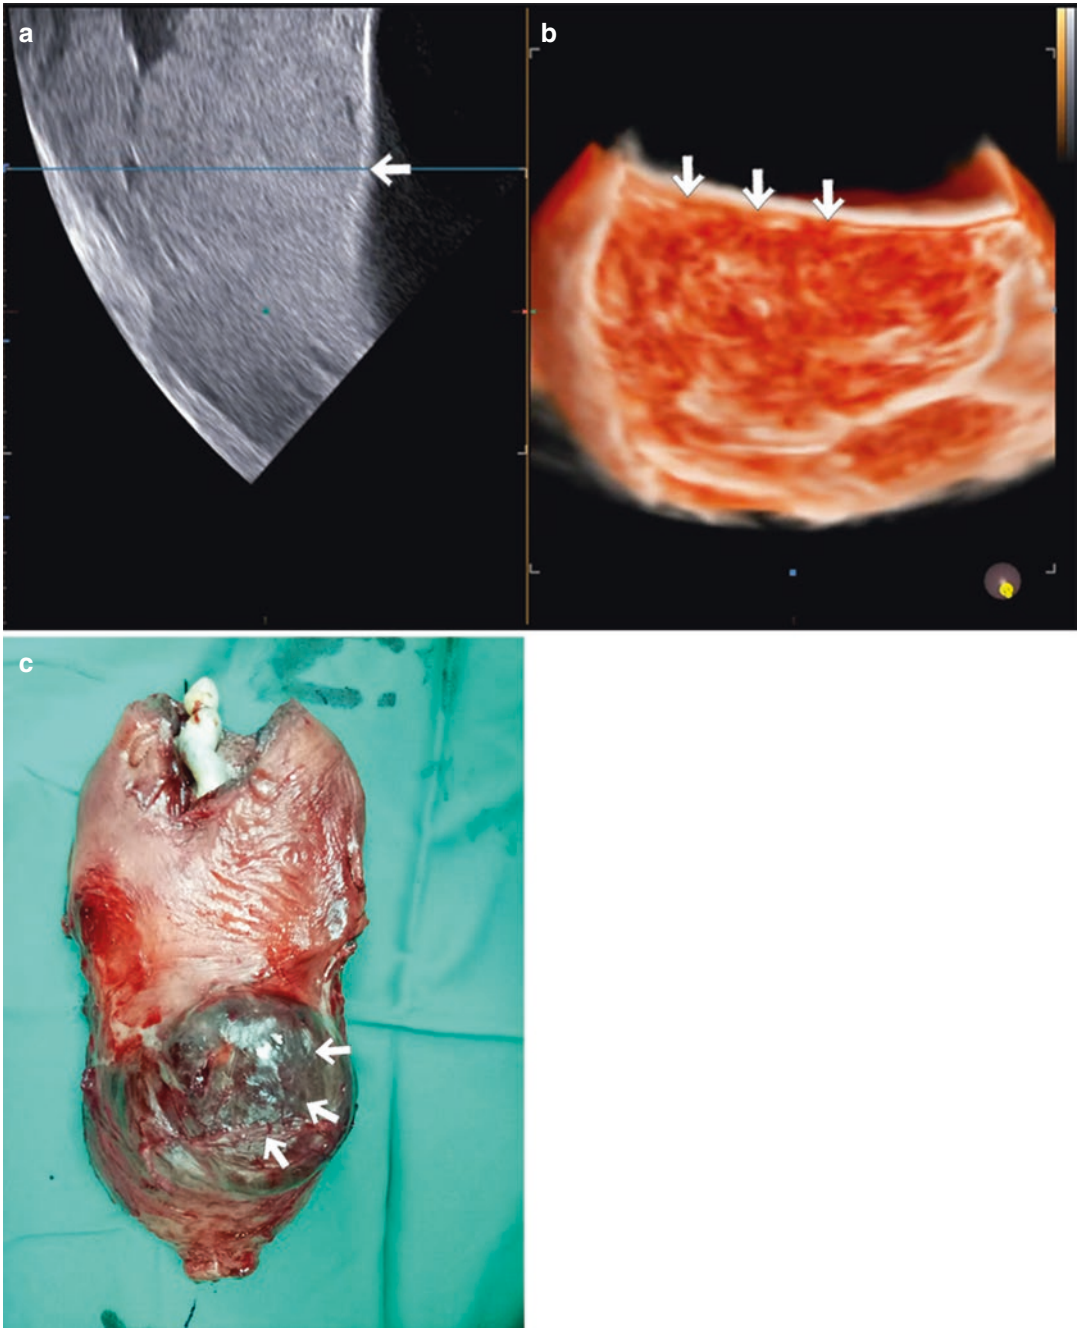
(a) Loss of “clear zone” and undetected myometrial wall (arrow), which is seen in (b) 3D volume rendering ultrasound (axial plane), which is predominantly a
